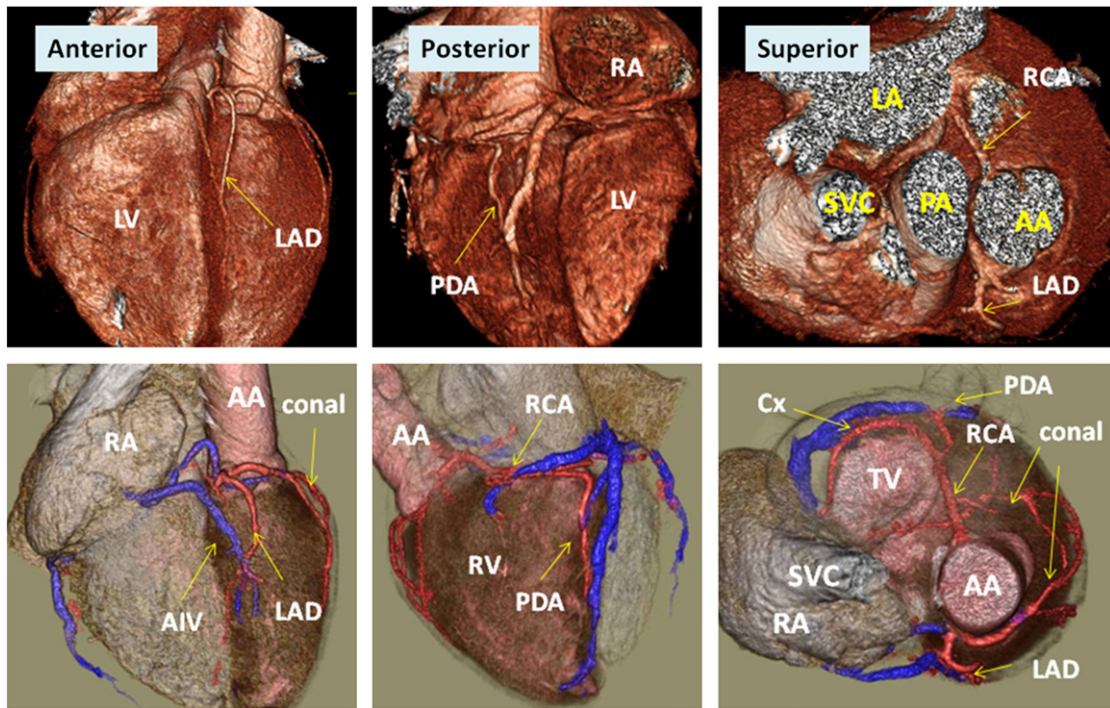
Volume rendered CT images before (upper row) and after color coding (lower row) in a patient with congenitally corrected transposition of the great arteries. Improved visualization of the complex vascular anatomy is shown after color coding. Note anomalous drainage of the anterior interventricular vein (AIV) into the right atrium (RA) and posterior course of the right coronary artery (RCA) dividing into the posterior descending artery (PDA) and circumflex artery (Cx). There is no circumflex artery arising from the left main or left anterior descending artery (LAD). AA = ascending aorta, LA = left atrium, PA = pulmonary artery, TV = tricuspid valve, RV = morphological right ventricle, LV = morphological left ventricle, SVC = superior vena cava.
